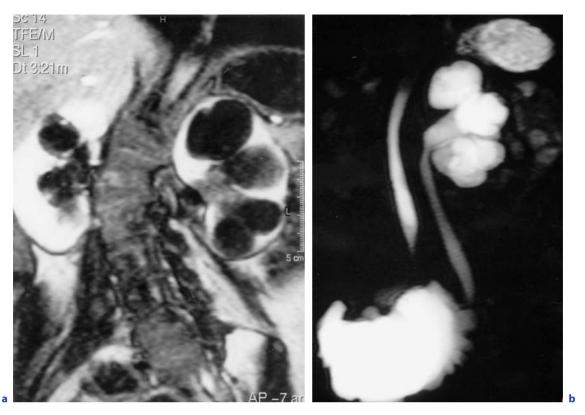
RN associated to neurogenic bladder as demonstrated on MR. a Turbo field echo T1 coronal sequence after gadolinium enhancement showing typical thinning of the renal parenchyma. b T2-weighted oblique coronal sequence displaying the left dilated collecting system and the neurogenic bladder
